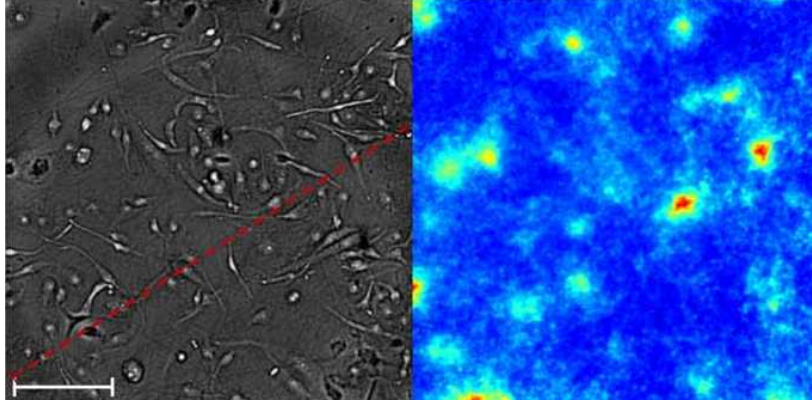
Brightfield (left) and radioluminescence (right) images of FDG uptake in single cells acquired with the RLM setup. The scalebar is 100 μm . From [92].
